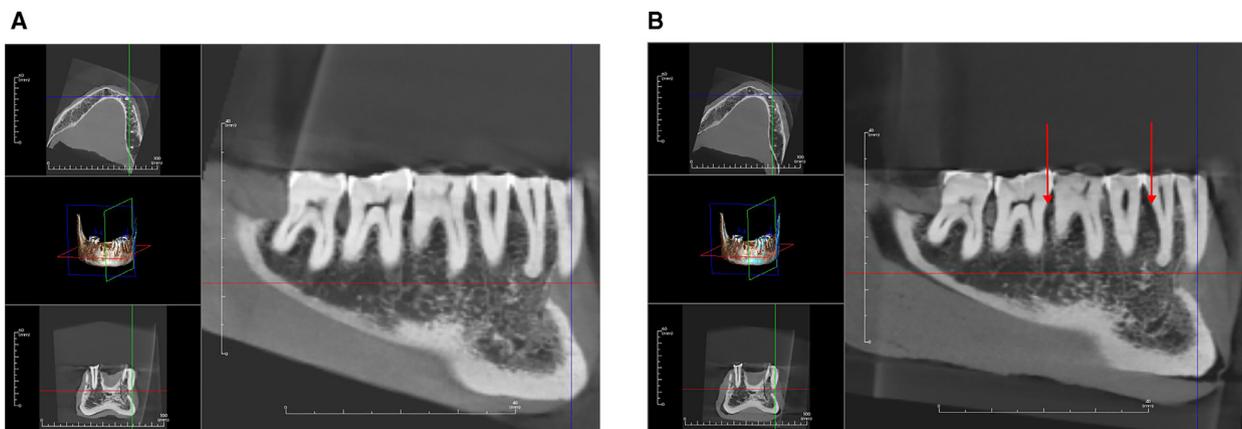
A, Superimposition window in Anatomage Invivo v. 5.4.5, with registered cone beam computed tomography (CBCT) scans showing the same quadrant as in Figures 2A and 2B without bone defects. B, Superimposition window in Anatomage Invivo v. 5.4.5, with registered CBCT scans showing the same quadrant as in Figures 2A and 2B with alveolar bone defects mesial to tooth #18 and distal to tooth #21 (red arrows). The defect mesial to tooth #18 was not visualized on the 2-dimensional radiograph. Defect depth mesial to tooth #18 was 5 mm with a remaining buccolingual bone wall thickness of 5 mm. Defect depth distal to tooth #21 was 6 mm, with a remaining buccolingual bone wall thickness of 3.5 mm.
